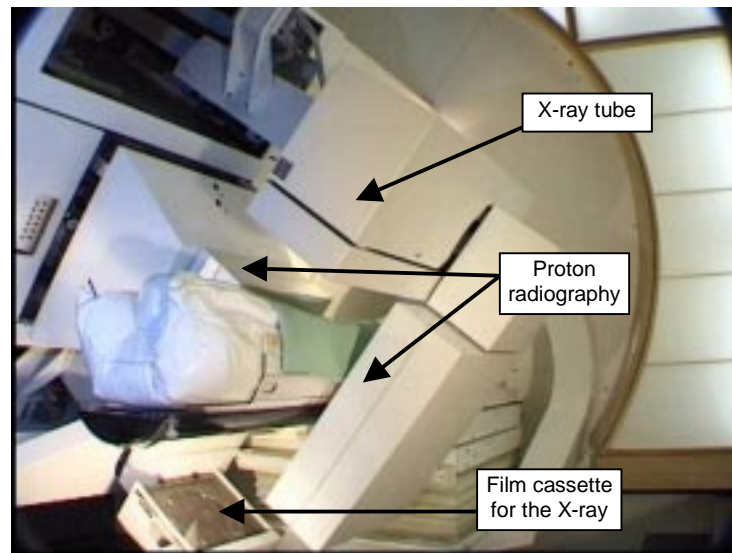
The X-ray and proton radiography at the PSI proton gantry. Source: PSI, 2000
